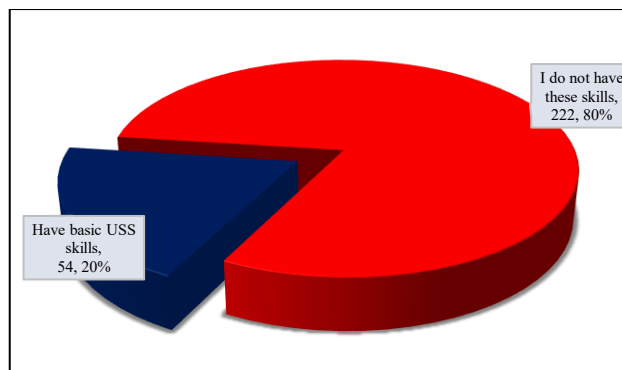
Possession of ultrasonographic skills among the PHC workers.
